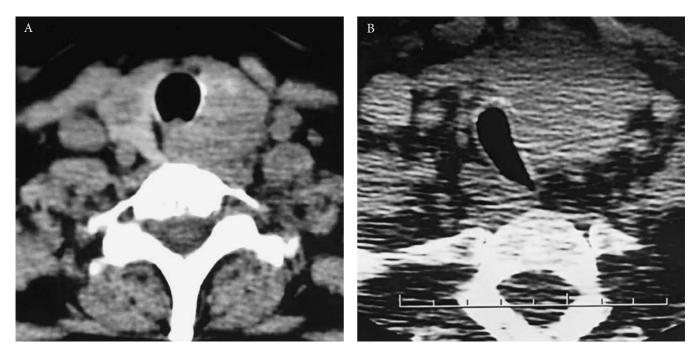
Computed tomography scans of invasion by differentiated carcinoma. A, In a 65-year-old woman with papillary carcinoma invading the trachea, esophagus, cricoid, and right recurrent laryngeal nerve. Treated by thyroidectomy, with tracheal resection and reconstruction. B, In a 51-year-old man with a very large papillary lesion invading and compressing the trachea. Resection with reconstruction was nonetheless possible because the length of trachea invaded was less than the total extent of tumor apparent on the scan. Six years later, the patient remained free of recurrence.
